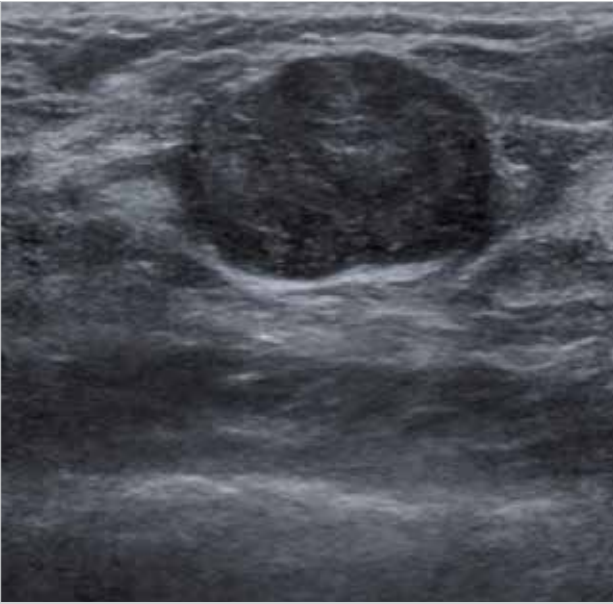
Ultrasonography showing fibroadenoma in the breast in the second patient
